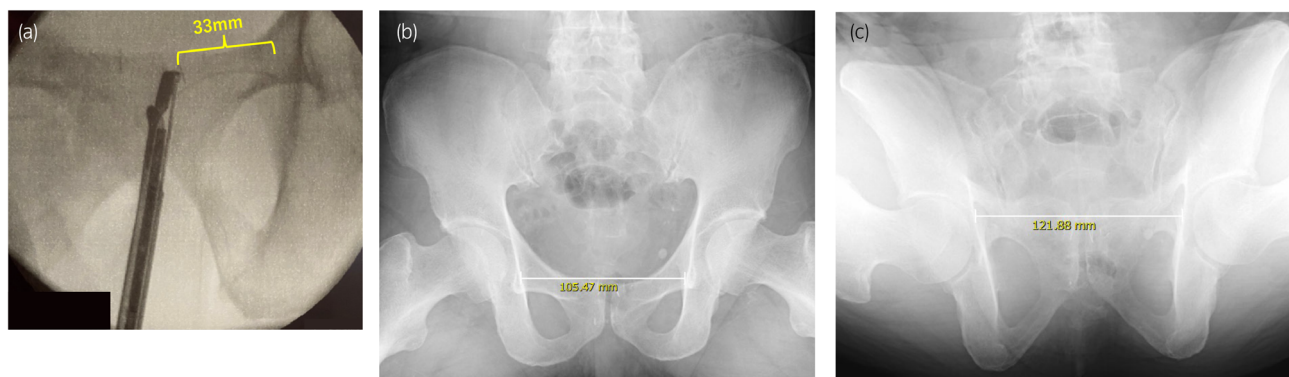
Pelvic X-ray image of the patients. (a) The delivery device has a needle length of 33 mm and increases the risk of damaging the pubic branches of the obturator artery and vein located at the superior and outer margin of the pubic symphysis. (b) Frontal pelvic radiograph after PUL with the patient in the low lithotomy position. The distance between the arcuate lines at the prostatic proximal urethral level was 105 mm. (c) Frontal pelvic radiograph after PUL with the patient in the high lithotomy position. The distance between the arcuate lines at the prostatic proximal urethral level increased to 122 mm.
